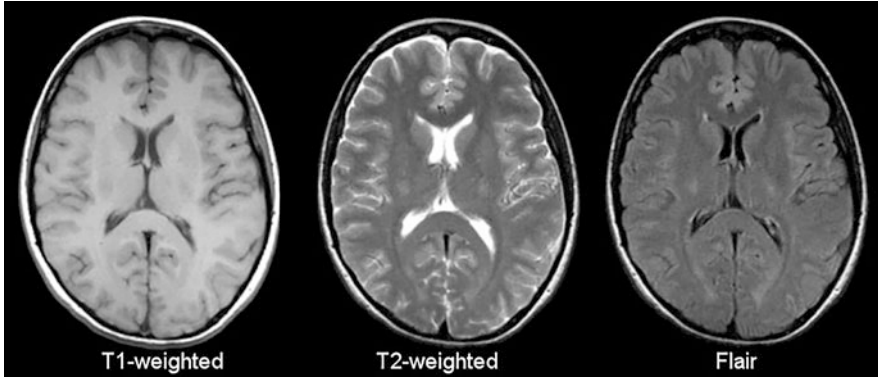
Examples of T1-weighted, T2-weighted, and FLAIR images [32]. Cerebrospinal fluid has high intensity on T2-weighted images
